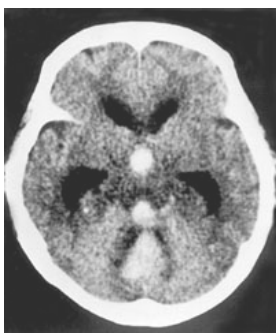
Native CT scan. Ventricular flood and hydrocephaly
